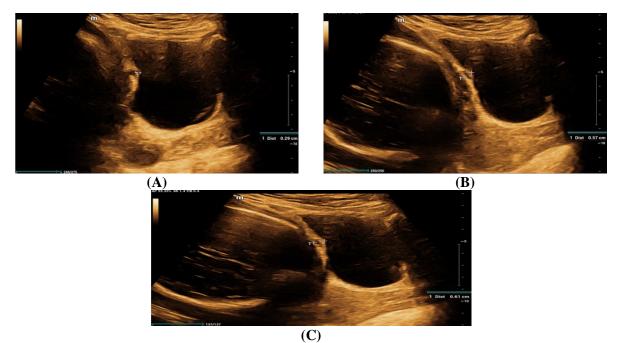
Ultrasound CS thickness (A) 2.9mm, (B) 5.7mm and (C) 6.1mm from our study
